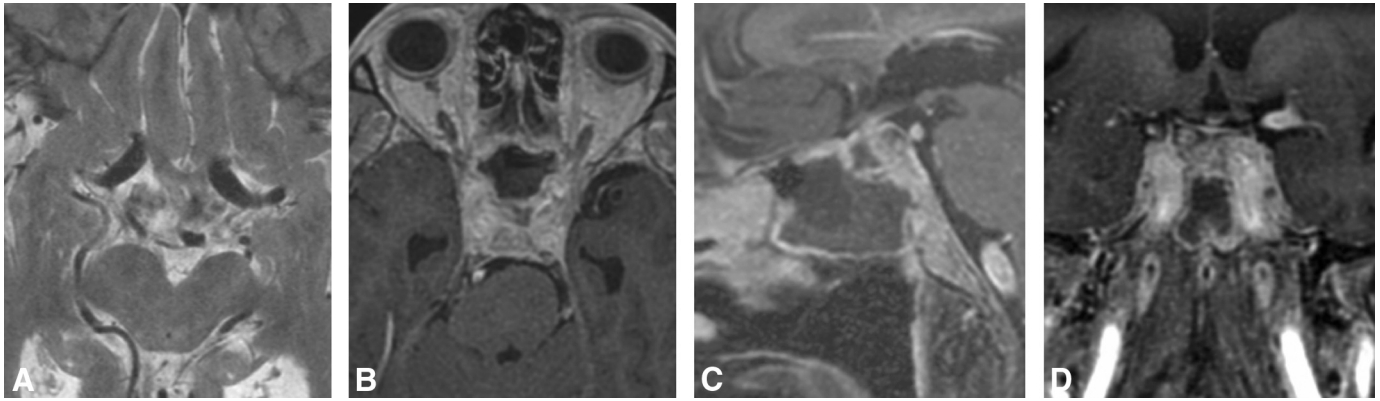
Aspergillosis. Axial T2WI (A), and axial (B), sagittal (C), and coronal (D) postgadolinium T1WI in a patient with aspergillosis. A 78-year-old man with a history of severe sinusitis and II, III, VI nerve palsies after bilateral sphenoidotomies for drainage and washout of a mucopycocele in the sphenoid sinuses. MR imaging demonstrates a defect in the anterior wall of the sella (C), through which the postoperative fluid collection in the sphenoid sinus is continuous with a small pocket of fluid either within or compressing the pituitary gland. The optic chiasm shows a tiny area of enhancement in its inferior aspect (C and D).
